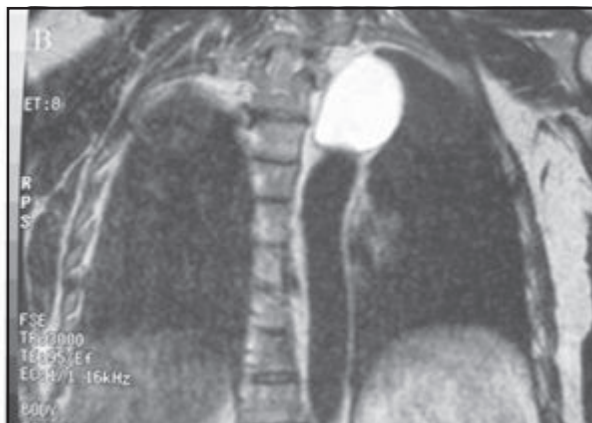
CT scan of Bronchogenic cyst
